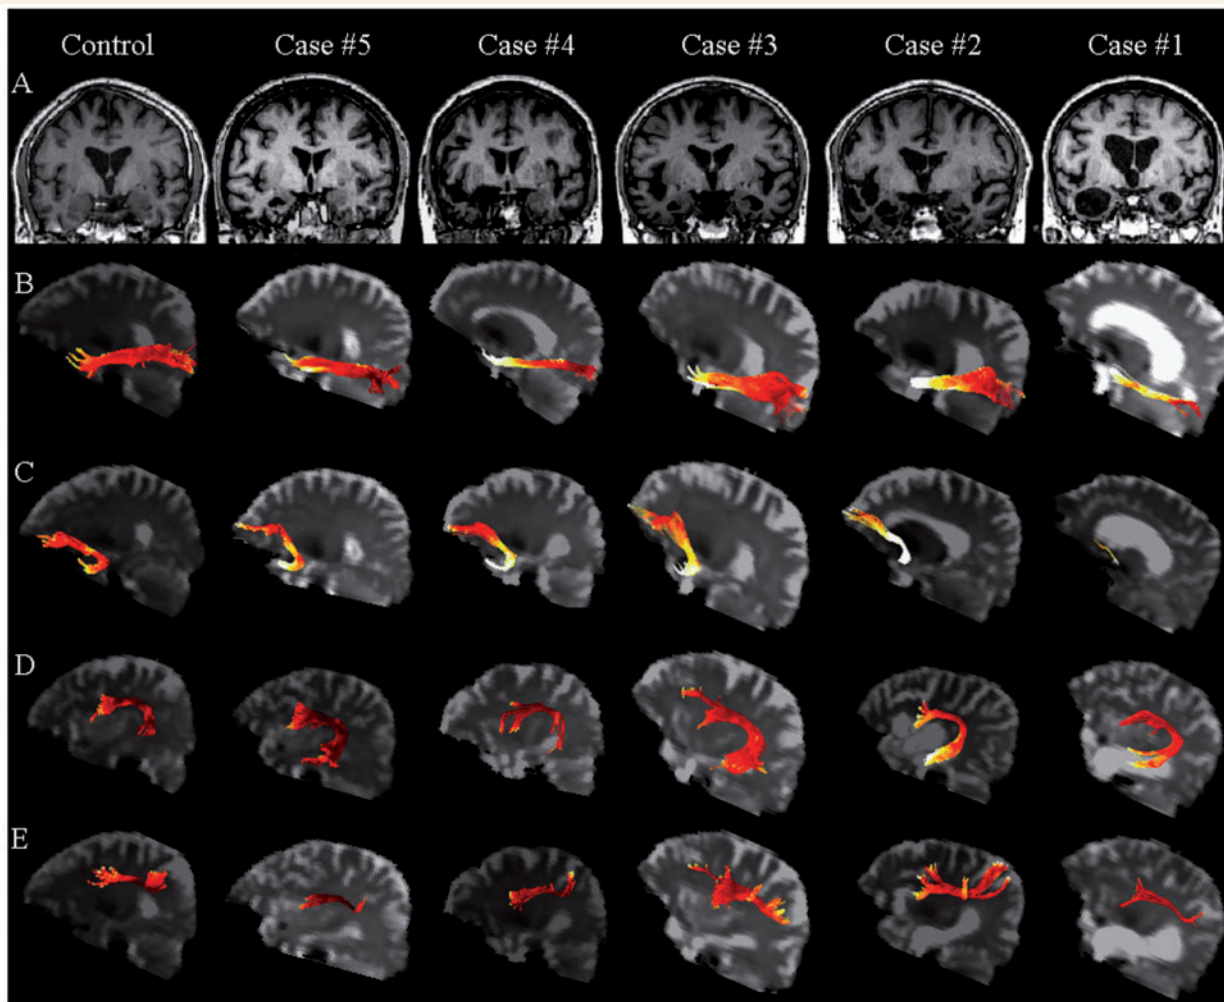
(A) Structural MRI of one representative control and each semantic dementia patient (coronal view). (B–D) Left language-related white matter tracts are rendered as maps of MD in one representative control and all patients (B: ILF; C: uncinatus fasciculus; D: arcuate fasciculus; E: fronto-parietal SLF). The colour scale represents the MD values going from lower (dark red) to higher values (yellow to white). Maximum damage is present in the anterior portion of the ILF and uncinatus fasciculus underlying the temporal pole.
